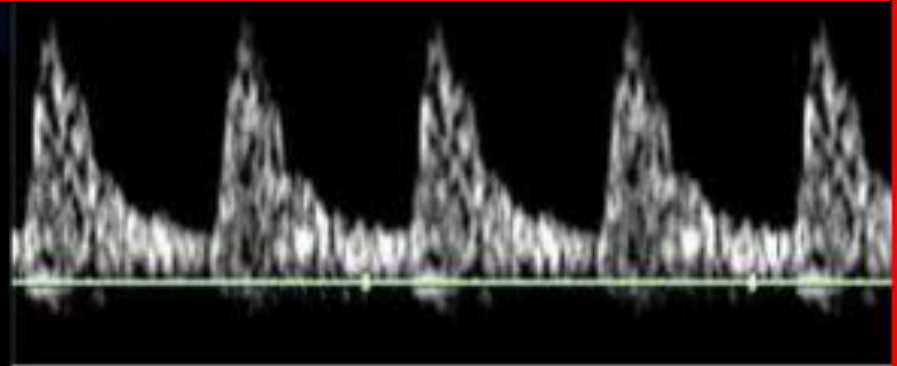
Normal and pathological uterine artery (1), umbilical arterial (2) and middle cerebral artery (3) Doppler waveforms. A compromised fetus will show a uterine artery waveform with 'notching', a reverse flow in the umbilical artery waveform and an increased diastolic component in the middle cerebral artery.
